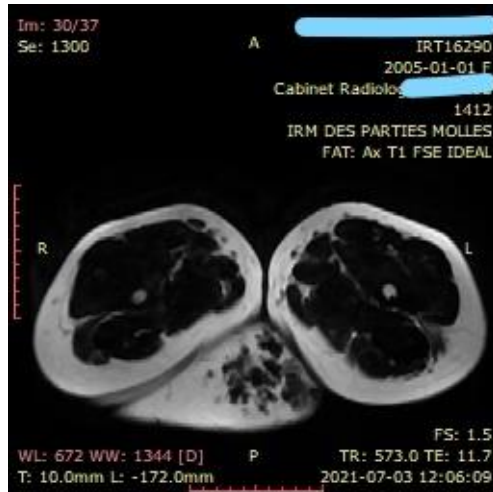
MRI section showing a plexiform neurofibroma
